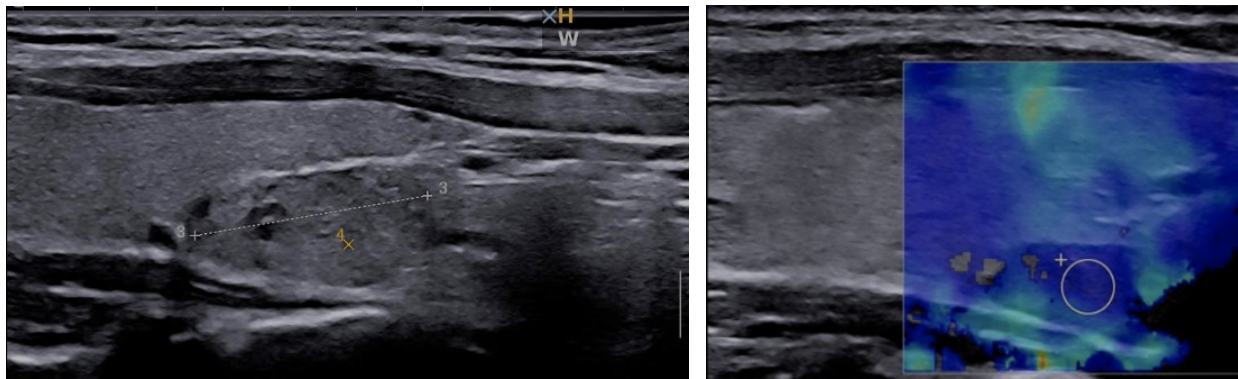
Right inferior parathyroid adenoma, extracapsular hypoechoic, oval structure on ultrasound (left), soft on elastography (right)
